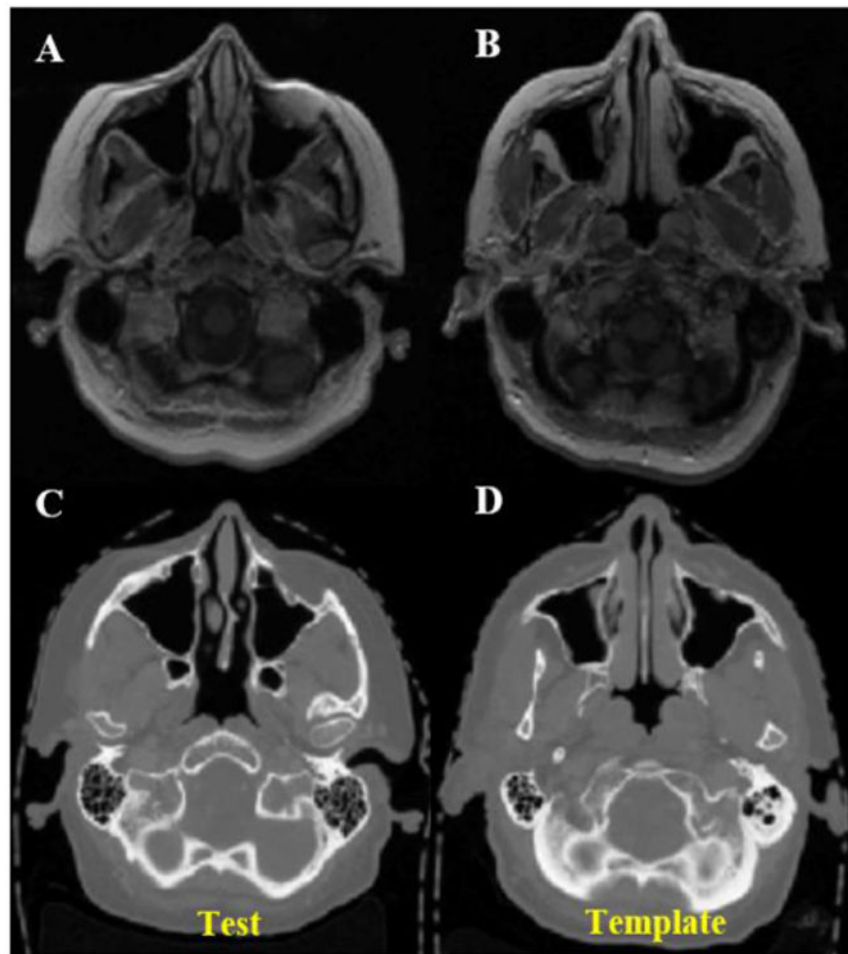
Axial views of MR (A, B) and CT (C, D) scans of test and template patients. Anatomical differences between the patients are noticeable.
